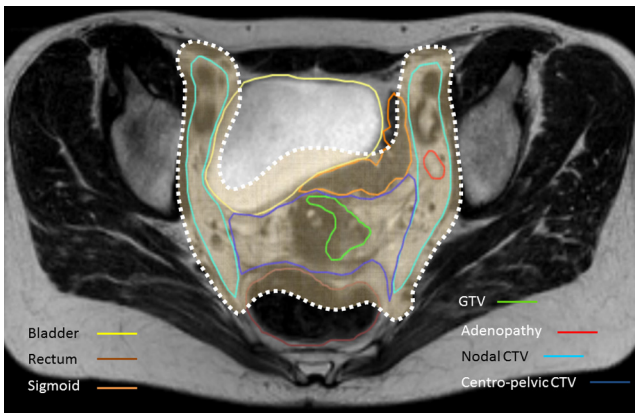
Generation of a PTV from a CTV by applying directional margins of 7 mm around the nodal CTV; 20 mm anteriorly, 15 mm posteriorly around the centro-pelvic CTV. White dashes: PTV. Axial T2-MRI.
